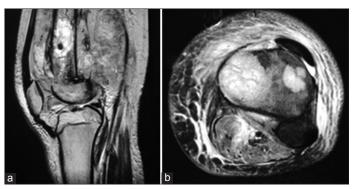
The magnetic resonance imaging showing the (a - T2 sag) hyperintense signal from mass arising from medullary cavity of metadiaphyseal area of the femur with anterior cortical breaching with permeation to suprapatellar area and (b) in PD A x F sat showed the intensity changes in proximal tibia which correlates to metastasis
